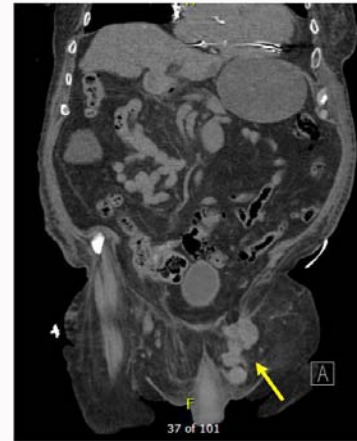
Follow up CT abdomen/pelvis showing enlarging left inguinal masses.
